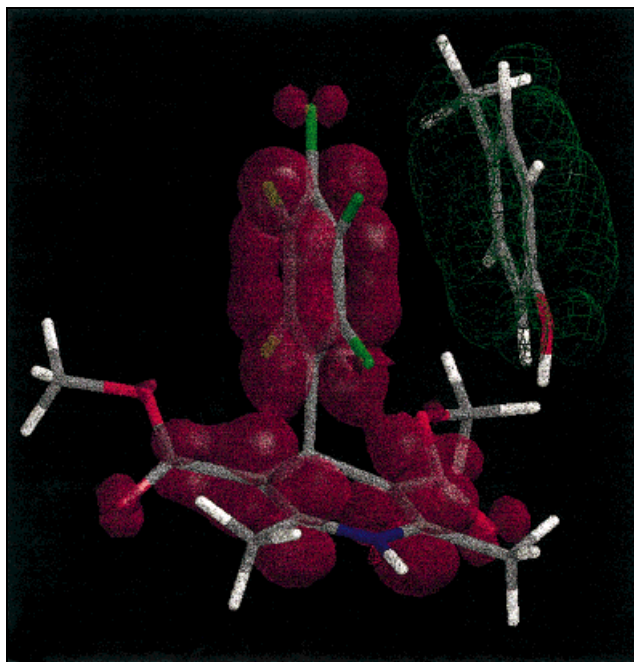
Hypothetical complex composed of p-cresol, representing a truncated tyrosine of the binding site, and the DHP derivative 1. The π -electron transfer from the HOMO (green grid) to the LUMO (red cloud) characterizes the postulated CT interaction
